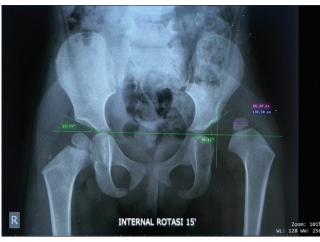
Pre-operative pelvic radiograph measurements
